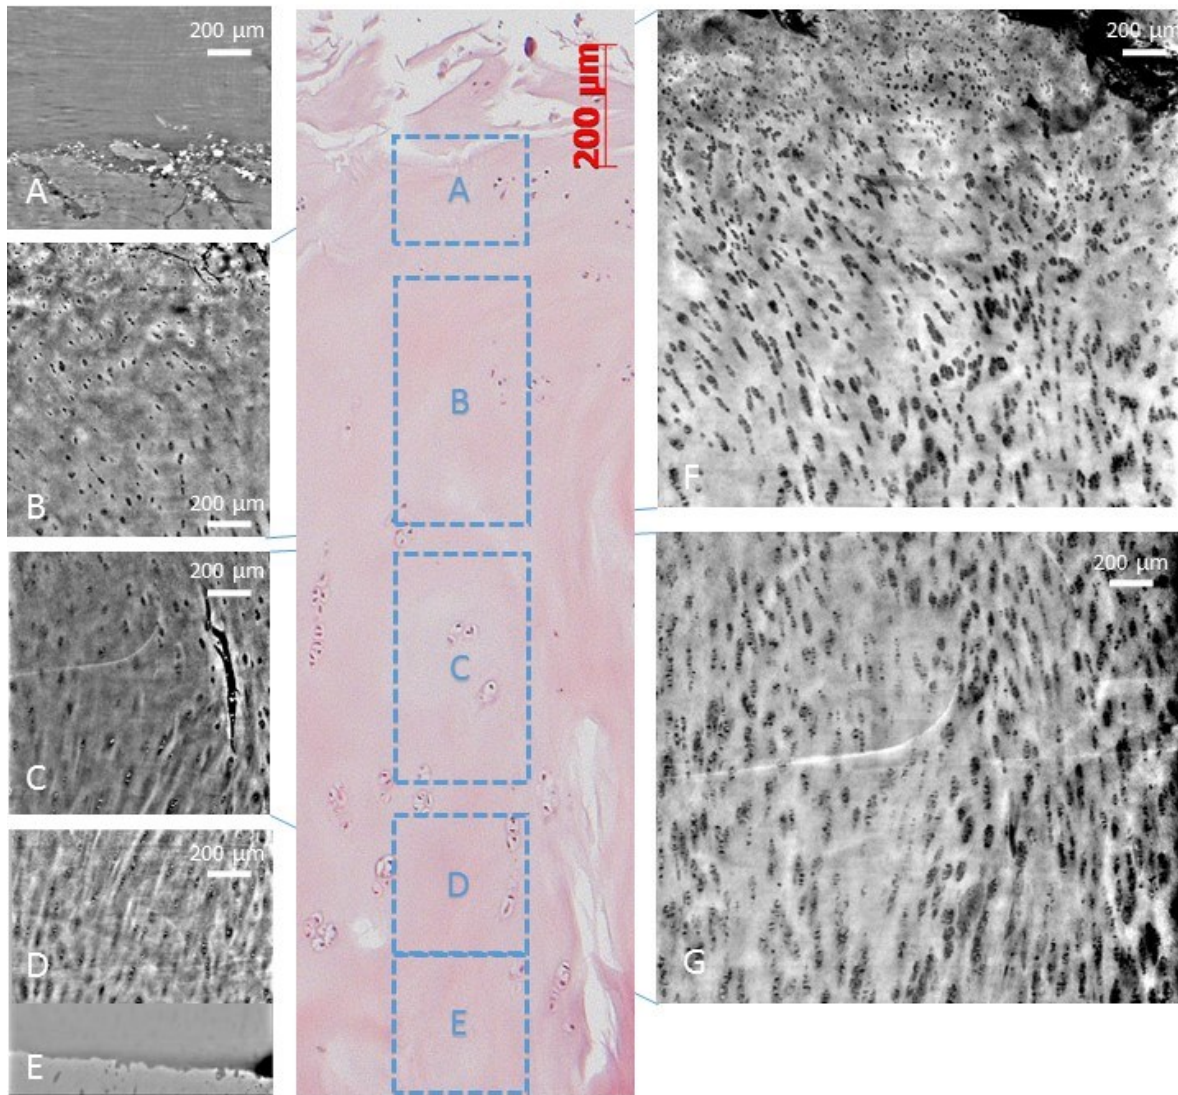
X-ray PCI sagittal images from ID17 high-resolution setup (effective pixel size $0.7 \mu\text{m}$); A)-E) different images from different areas of sample F) Z-Projection of the transition between superficial zone and mid zone
